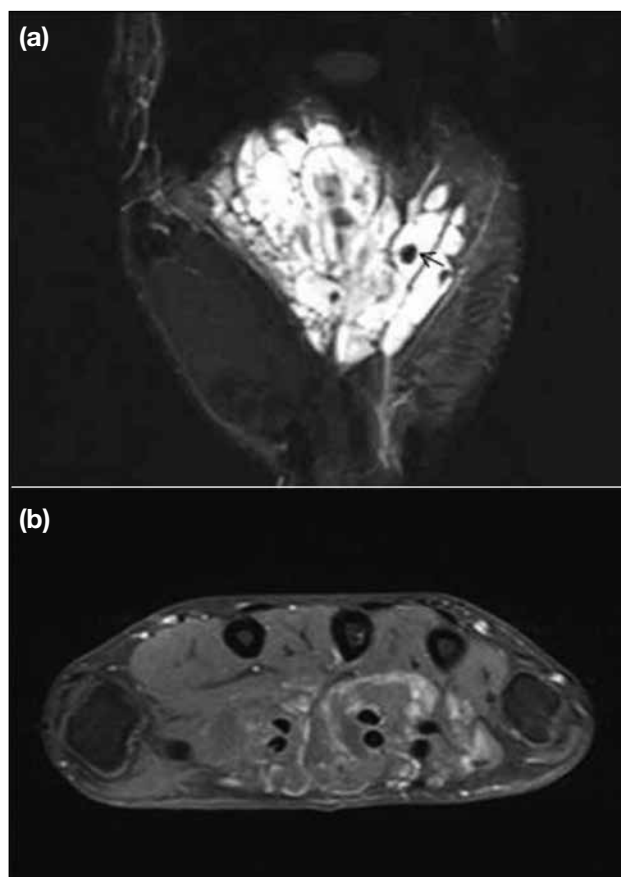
This is the same patient as in Figure 9 and 10a. T2-weighted short-tau inversion recovery coronal magnetic resonance image showing a multilobulated hyperintense lesion with extension from the level of the distal carpal row proximally to the metacarpophalangeal joint level distally. Internal low-signal-intensity foci are suggestive of phleboliths (arrow). (b) Post-contrast T1-weighted fat-saturated magnetic resonance image showing patchy peripheral contrast enhancement. The diagnosis is venous malformation.
